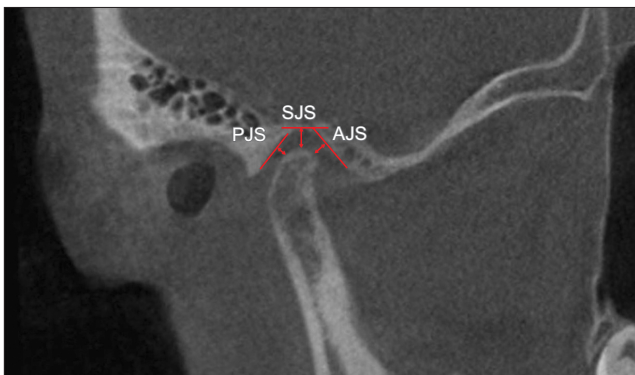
Joint space measured in the sagittal plane of a cone-beam computed tomography image of the temporomandibular joint. AJS, anterior joint space; SJS, superior joint space; PJS, posterior joint space.
